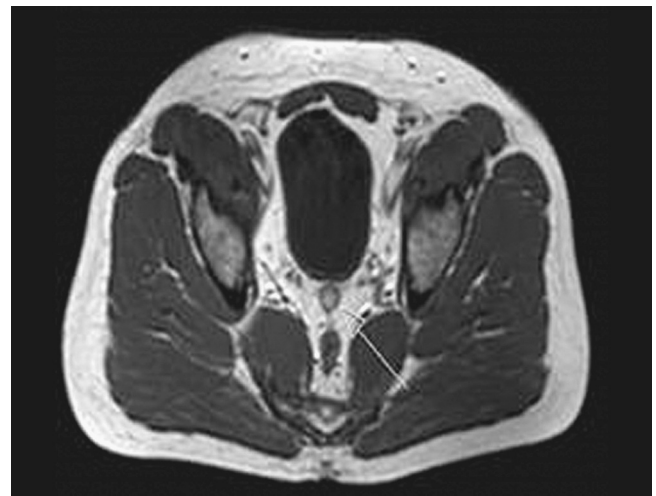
Axial T1 weighted MR images revealed that central of the lesion has similar intensity to the fatty tissue correlated with epiploic appendagitis.
